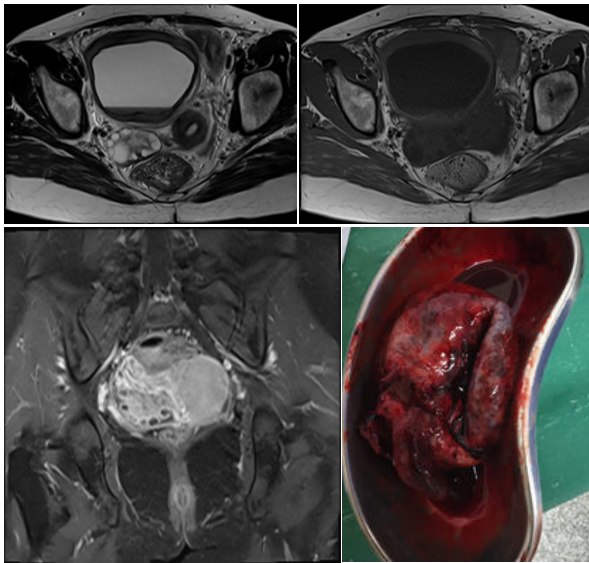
MRI showing enlarged ovary with peripheral follicles.
